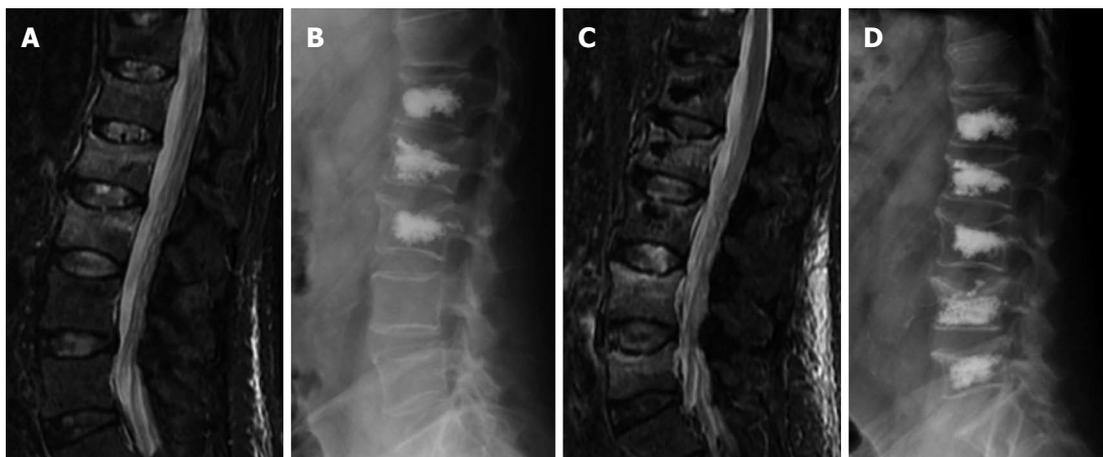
Sagittal STIR magnetic resonance image (A) shows fractures with edema of L1 to L3. Kyphoplasty was performed in these vertebrae (B), 3 wk later back pain returned and magnetic resonance imaging showed development of new fractures in L4 and L5 (C), vertebroplasty was performed at these levels (D).
